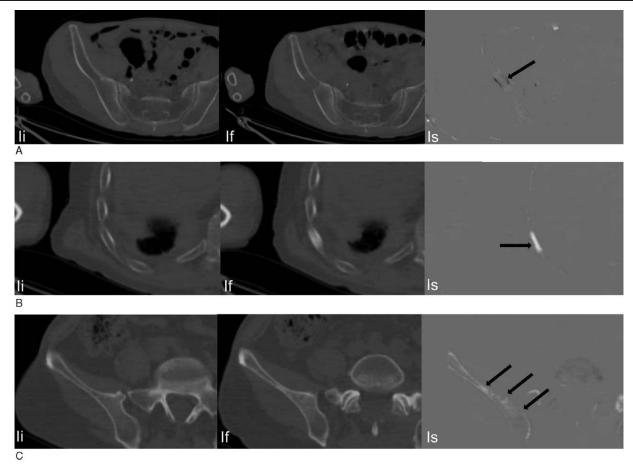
Lytic, Sclerotic, Mixed bone metastases in TS image. The TS images generated from the 3.75 mm CT images. The TS images indicate the bone metastases (arrows) with various appearances (li, initial CT images; If, follow up CT images; Is, TS images). (A) A case of a 70-year-old man with a history of lung cancer with an osteolytic lesion in the right ilium. The osteolytic lesion appears as hypointense on the TS image. (B) A case of a 64-year-old man with a history of lung cancer with an osteoblastic lesion in the 6th right rib. The osteoblastic lesion appears as hypointense on the TS image. (C) A case of a 64-year-old man with a history of lung cancer with a mixed osteolytic and osteoblastic lesion in the 6th right rib. The osteoblastic lesion appears as hyperintense on the TS image. (C) A case of a 64-year-old man with a history of lung cancer with a mixed osteolytic and osteoblastic lesion in the right ilium. The mixed osteolytic and osteoblastic lesion has a heterogeneous intensity on the TS image. CT = computed tomography, TS = temporal subtraction.
